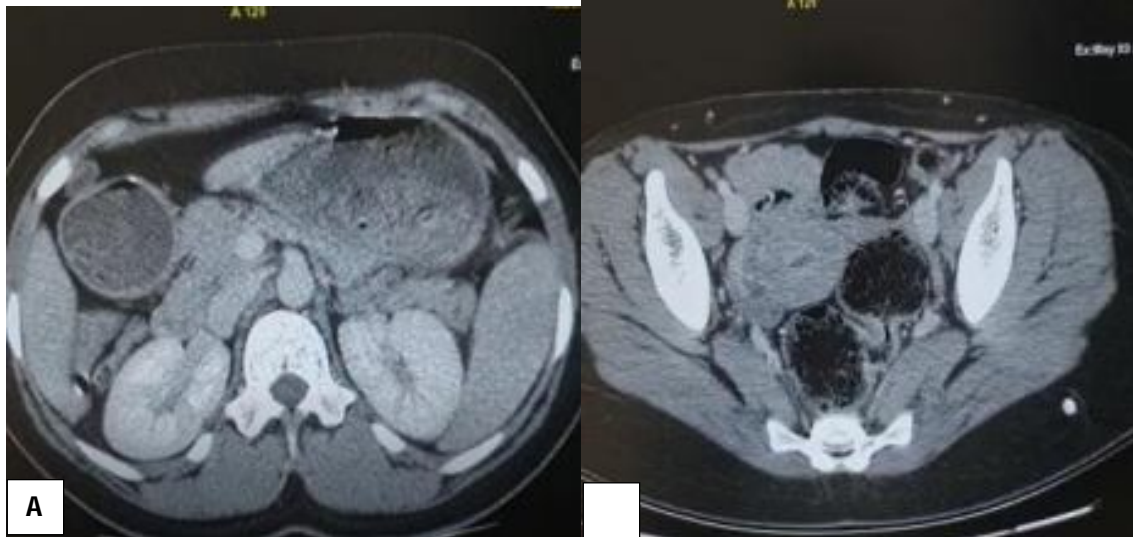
A follow-up CT scan after treatment
